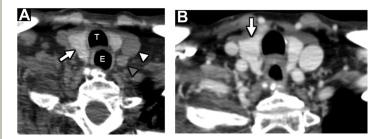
Axial CT imaging of thyroid. (*A*) The thyroid is intrinsically hyperdense on unenhanced CT (*white arrow*). The common carotid artery (*gray arrowhead*) and internal jugular vein (*white arrowhead*) are posterolateral to the thyroid. Esophagus (E) is located posterior to the thyroid, whereas the trachea (T) is located anterior to the esophagus. (*B*) Contrast-enhanced CT shows avid enhancement of the thyroid (*white arrow*).
